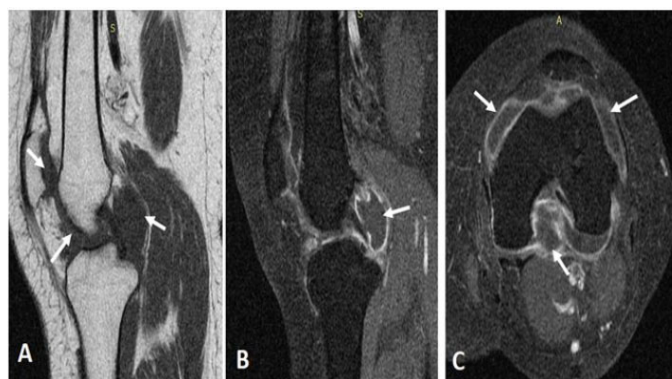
Knee MRI in T1 sagittal plane (A), T1 Fat Sat sagittal plane (B), and axial plane (C) showing well-limited synovial and intra-articular nodular formations in hyposignal (arrows).
